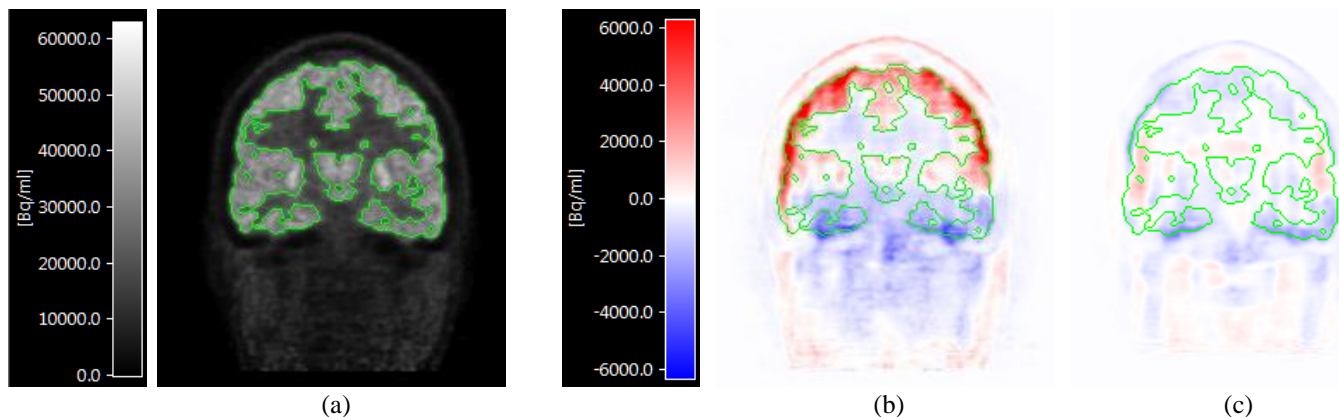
Visual assessment of difference between using CT-based and HRRT μ -maps on FDG scans (subject 4). (A) FDG (EM) with a threshold contour, (B) $EM_{\mu\text{-MAP-TR}} - EM_{\mu\text{-CT}}$ and (C) $EM_{\mu\text{-TXTV}} - EM_{\mu\text{-CT}}$. The contour from A is overlaid on B and C. The scale for the subtraction images are set to $\pm 10\%$ of the maximum value in (A) and the images show that while TXTV still has some minor differences from CT-based attenuation correction, MAP-TR has more severe differences (confirming the general findings shown in Fig. 6).
